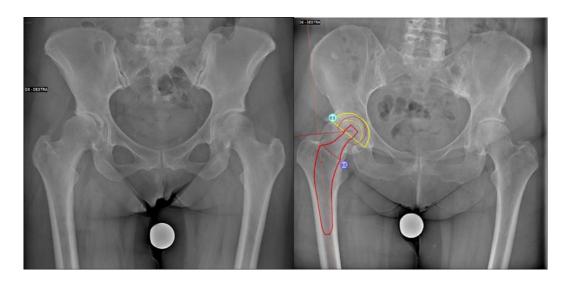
Preoperative planning is typically based on an anteroposterior x-ray of the pelvis.
